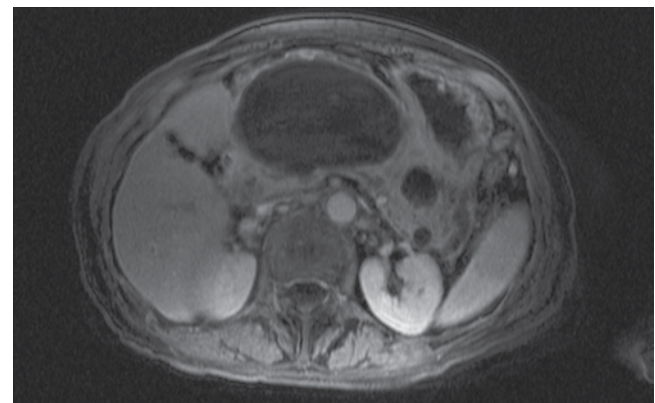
Magnetic resonance imaging with contrast revealing 11x7cm non-enhancing cystic lesion within the body of the pancreas corresponding to a pancreatic pseudocyst with internal debris. Additional small cystic lesions in pancreatic tail likely represent additional smaller pseudocysts and areas of pancreatic ductal dilatation.
